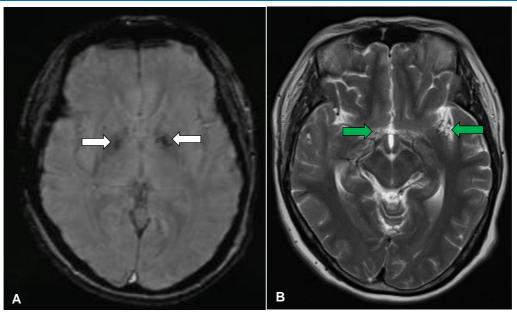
Brain magnetic resonance imaging (MRI) with contrast in axial section: (A) SWI sequence showing hypointensities in bilateral basal ganglia (white arrow), corresponding to stasis of dilated draining veins. (B) T2 sequence showing moyamoya vessels (green arrow) in the territory of the bilateral anterior cerebral artery and the territory of the left middle cerebral artery.
